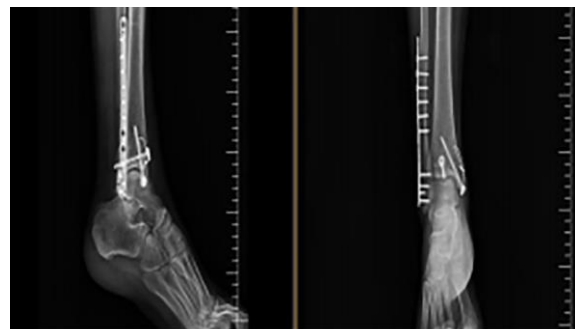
Postop Ap-Lateral ankle radiography
